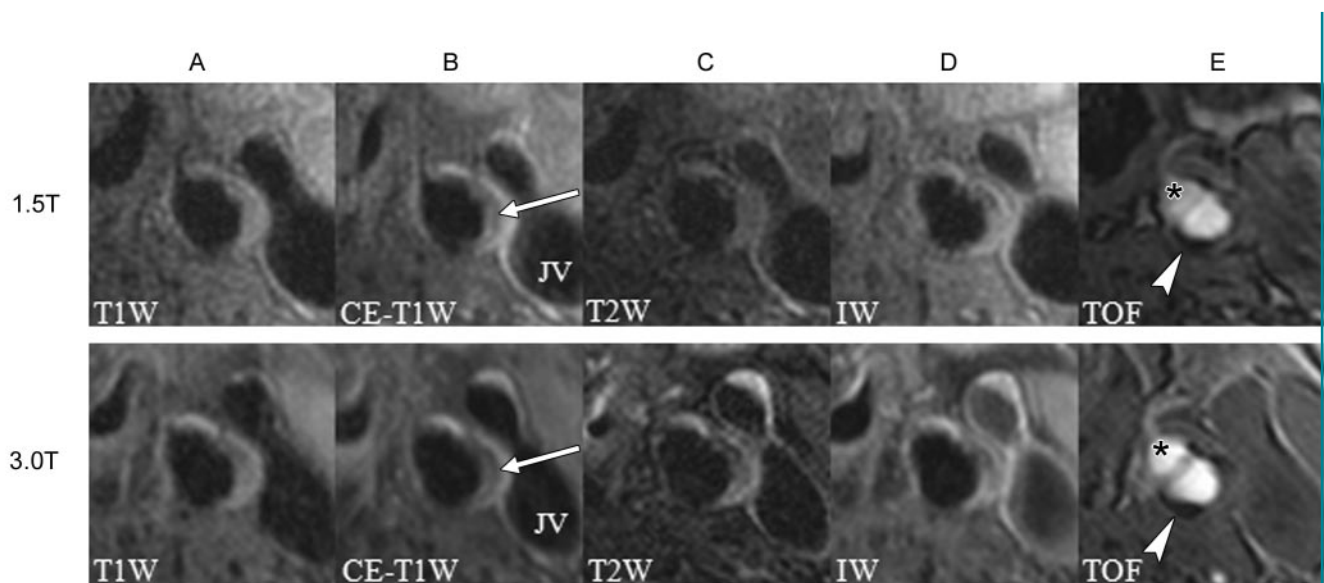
Matched axial cross-sectional images of left carotid bifurcation in 68-year-old man at 1.5 T (top) and 3.0 T (bottom). A lipid-rich necrotic core (column B, arrows) is apparent because of the decrease in signal intensity on the contrast-enhanced T1-weighted image (*CE-T1W*) compared with that on the precontrast T1-weighted (*T1W*) image and in surrounding fibrous tissue. The isointense signal on the TOF image in this region is consistent with an absence of hemorrhage at this location. Note the similarity in size of the lipid-rich necrotic core in the absence of hemorrhage. Other features of note: Superficial calcification (arrowheads, column E) is present with both platforms, and a branching vessel (* in column E), most likely the superior thyroid artery, is also present. *IW* = intermediate weighted, *JV* = jugular vein, *T2W* = T2 weighted.
